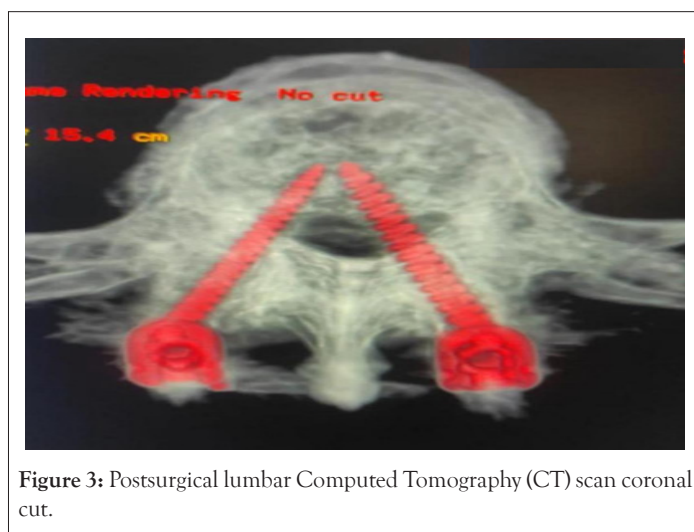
Postsurgical lumbar Computed Tomography (CT) scan coronal cut.
